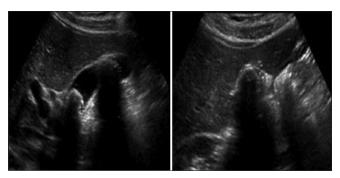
Wes sign. Sagittal and transverse ultrasound images of the gallbladder showing the wall-echo-shadow complex, comprised of an outer echogenic line representing the gallbladder wall, an outer hypoechoic line representing the gallbladder lumen, an inner echogenic line, representing the margin of the gallstone, and then strong posterior acoustic shadow
